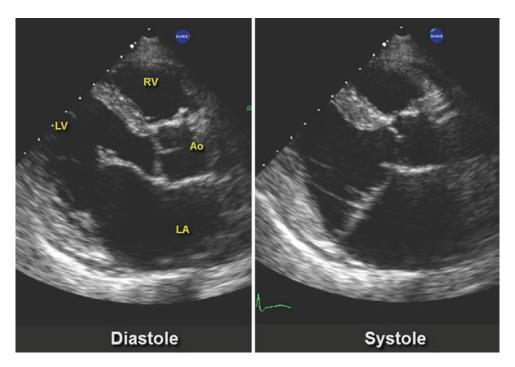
Parasternal long axis of a patient with mitral prolapse. The mitral valve is open in diastole (left panel) and closed in systole (right panel) with leaflets prolapsing
